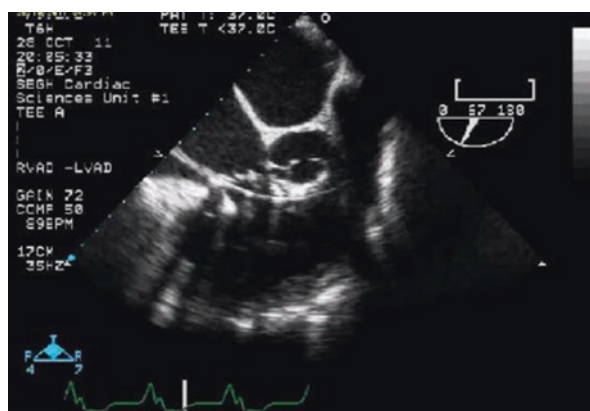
Correct Impella RP catheter position on transesophageal echocardiogram, mid-esophageal long-axis view optimized for tricuspid valve
